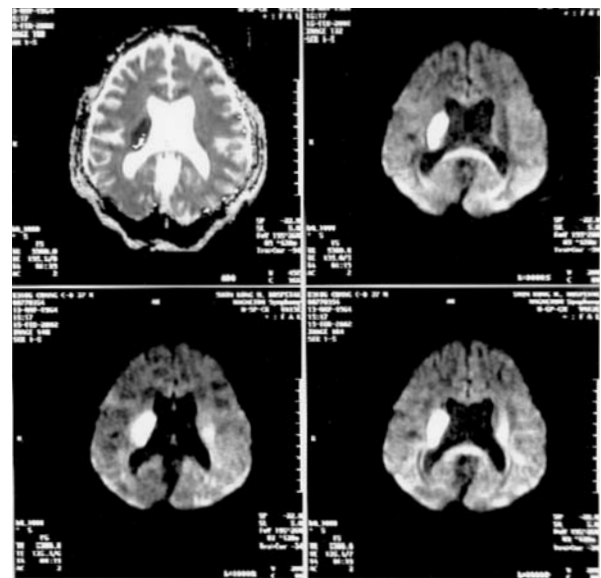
Only one of the two lesions in Fig.1 had bright signal in DWI study. It has a diameter of ~2 cm.
